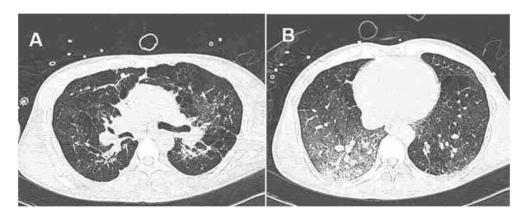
HRCT showing interstitial thickening and a few areas of traction bronchiectasis mainly in the upper zone with some emphysematous changes
